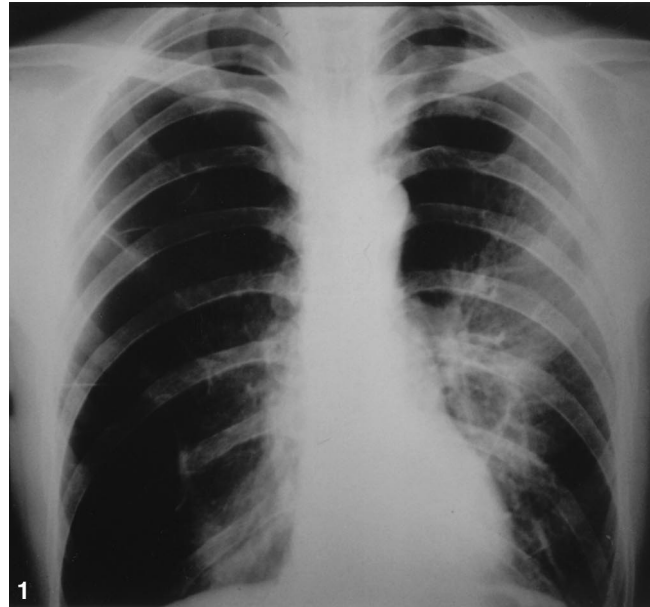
Chest radiograph demonstrates bullae in both lungs.
